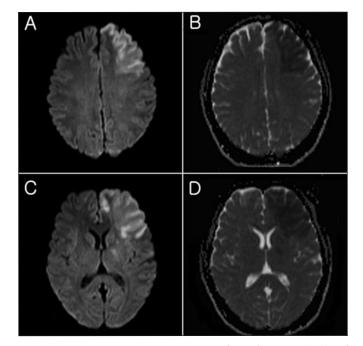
MRI of the brain showing increased signal on DWI (A, C) and low signal intensity on ADC (B, D) maps in the territory of the left MCA and the left ACA. MRI, magnetic resonance imaging; DWI, diffusion-weighted image; MCA, middle cerebral artery; ACA, anterior cerebral artery.
